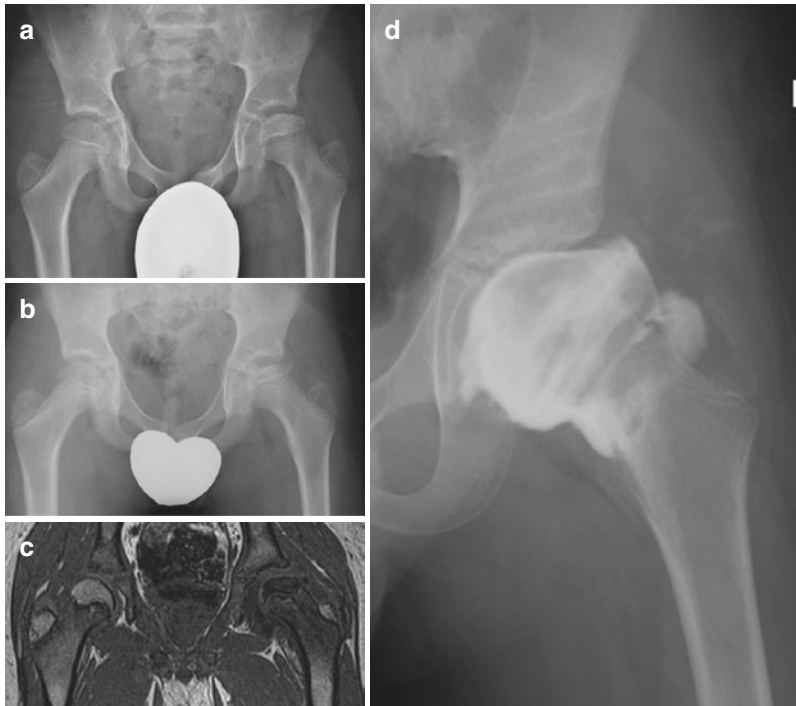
(a) An 8-year and 10-month-old boy diagnosed with left-sided Perthes. There is already a slight increase in medial joint space and a small break in Shenton's line. The subchondral fracture can be seen. (b) Four months later the femoral head suddenly collapsed with increased pain and limitation of motion. There is more extrusion. (c) Pre-op MRI showing increased medial joint space, lateral extrusion and flattening of the femoral head. Note the marrow signal change in the femoral epiphysis compared to the opposite side. (d) Arthrogram left femoral head showing the flattening, extrusion, and medial dye pool. (e) Fixator placement starts with insertion of a center of rotation Steinmann pin into the femoral head (left). The pin is placed superior to the center of the head so that it ends after distraction in the center of the acetabulum. The unilateral external fixator is mounted on this pin through the cannulation in the hinge (left center). The pelvic pins are inserted at an oblique angle to the pelvis in order to abduct the hip (right center). A wire is inserted first followed by a cannulated drill bit followed by the threaded half pin. The arch is connected to the pins proximally. The hip is distracted acutely and the center of rotation pin removed and reinserted. Note that it lies in the center of the acetabulum and not the center of the femoral head which has been moved distally (right). (f) AP radiograph of both femurs and pelvis showing the abducted position of the left femur to the pelvis. There are four multiplanar pins in the pelvis and three in the femur. The rail is parallel to the femur shaft. The hip is overdistracted and Shenton's line is over-reduced. The femoral head was moved medially and distally. (g) Only 2 months later the femoral head height is already increased and fills the distraction space created. Note the arch on the distal femur used to connect an anterior extension bar between the two arches. (h) Arthrogram of hip joint after removal of the external fixator. Note the rounding of the femoral head. (i) Femoral head immediately after removal. The lateral pillar is ossified, and the central portion, which has expanded, has some dead bone evident in its center (white sequestrum). (j) AP and frog lateral pelvis X-rays 4 years after distraction (age 13 years). The femoral head is now fully ossified. Both femoral head physes are about to close. The femoral head shape can be classified as a Stulberg Class 2. The acetabulum appears to be dysplastic due to the relative coxa magna. The patient has full range of motion of left hip and has no limp. ((C) Dror Paley. Used with Permission)
